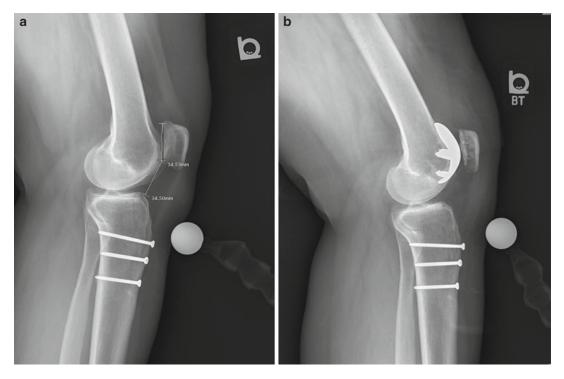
(a) Preoperative lateral radiograph and (b) postoperative lateral radiograph
